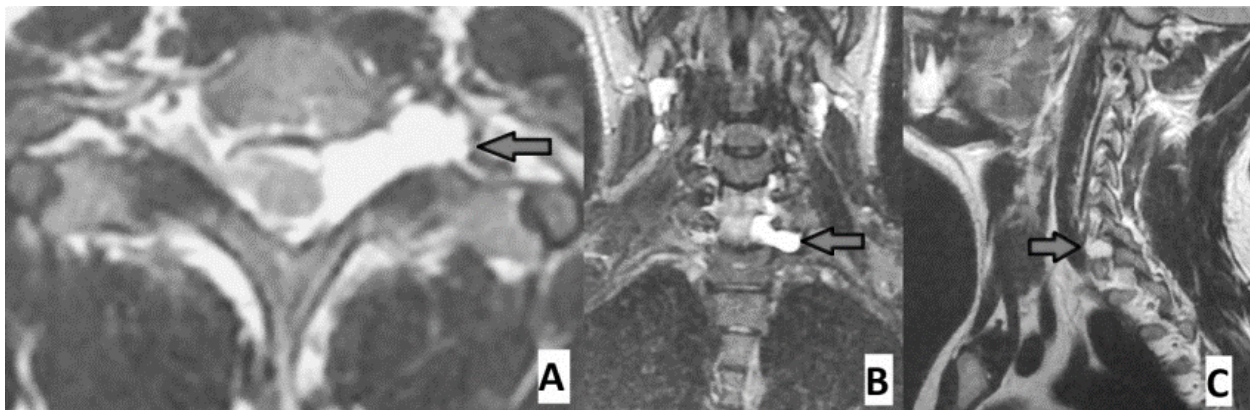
Preoperative cervical spine MRI in T2 weighted images, in patient suffering from brachial plexus avulsion; A: axial slide, B: coronal slide, C: sagittal slide; the arrow shows a pseudomeningocele characteristic lesion of brachial plexus avulsion.
